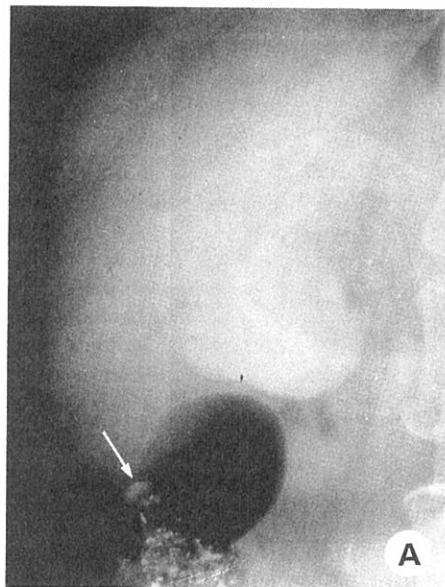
(MF [redacted]). A. Oral cholecystogram shows a calcification outside the projection of the gallbladder (arrow). B. Subcostal ultrasonography shows a bicameral gallbladder (g) and a calculus in its fundal chamber. L=liver.
